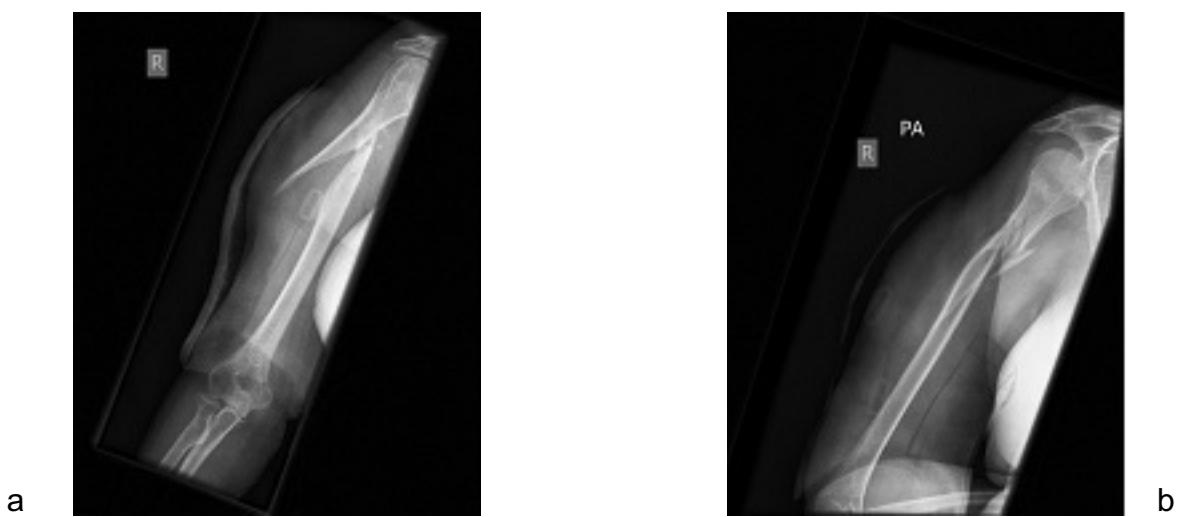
Radiographs of a 75-year-old female showing humeral shaft fracture displaced in abduction
